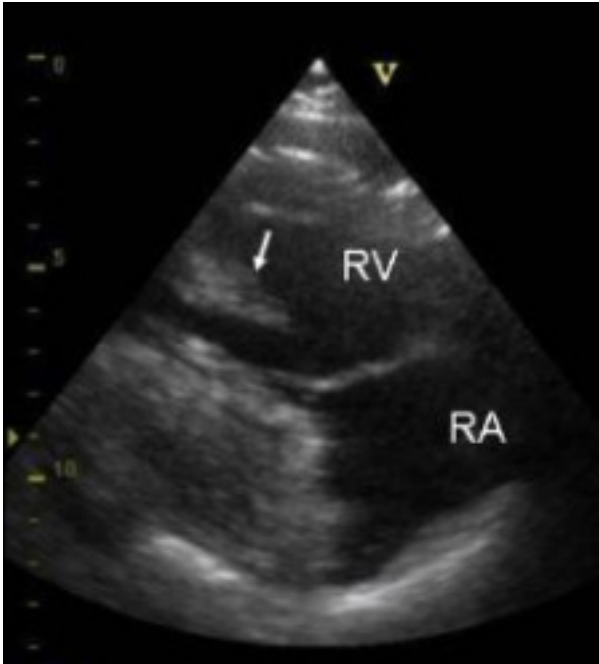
Parasternal long axis view demonstrating mass shaped hypertrophic papillary muscle in right ventricular apex. RA-Right atrium, RV-Right ventricle, White arrow- hypertrophic papillary muscle mimicking mass.
